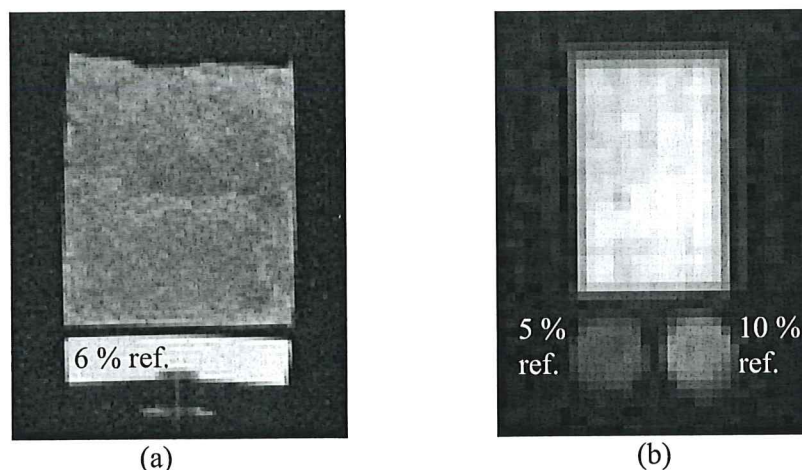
(a) Spin-echo MRI and (b) SPRITE MRI image of the same sample. Salt content determined chemically was 15.8 %.
